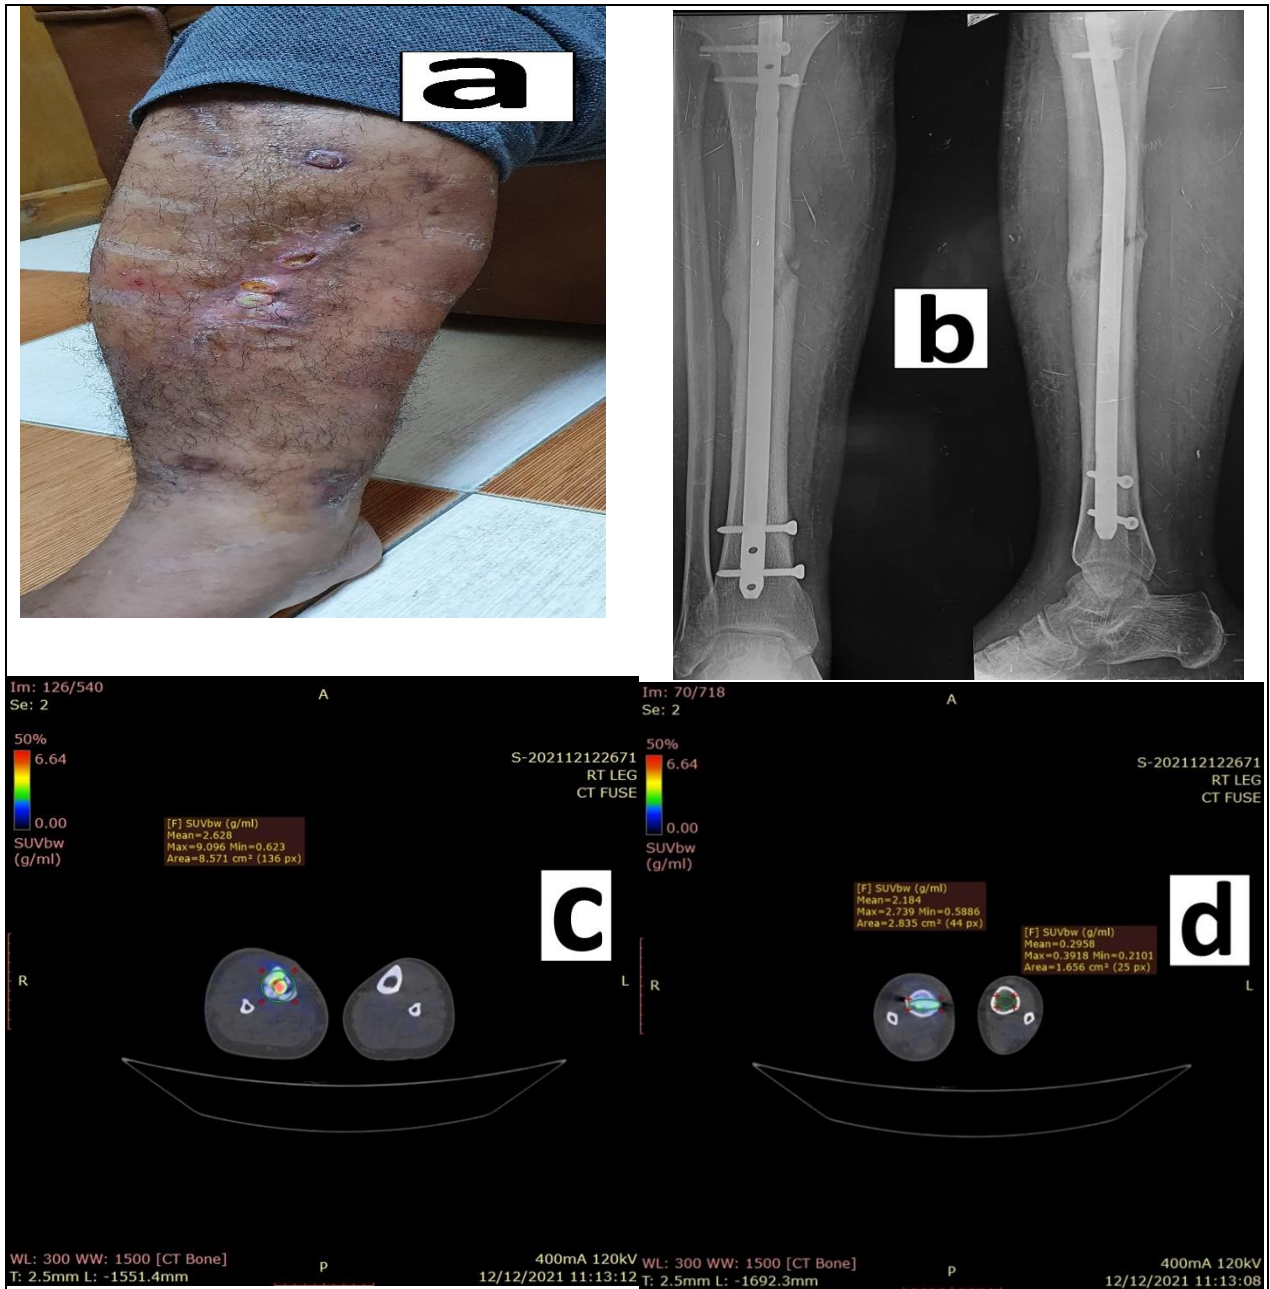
A 32-year-old smoker male (No. 4) had closed fracture mid-shaft right tibia treated by closed intramedullary nailing. Infection occurred one month later (a) The patient at presentation with infection duration of five months (b) The radiographs at presentation (c) PET/CT SUV_{max} at the red zone (HUA) was 9.09 (d) At the green zone (LUA), SUV_{max} was 2.73. The six samples from the red (fracture site) and green (distal locking screws) zone grew MRSA (i.e., the same organism).
